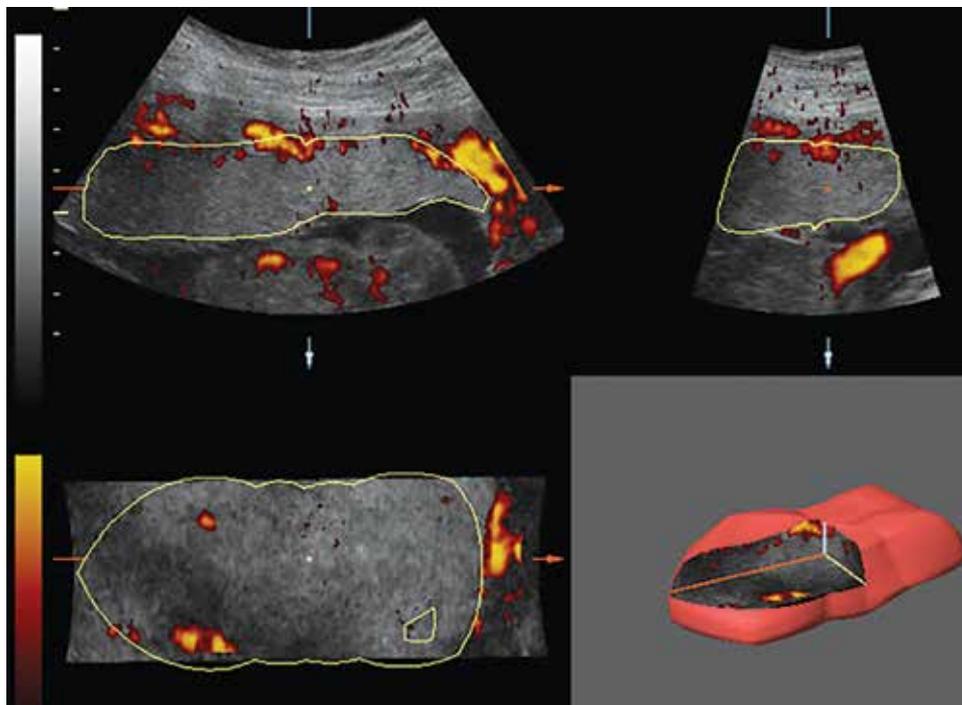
Three orthogonal planes of the placenta. Three-dimensional power Doppler reconstruction is shown in the right lower quadrant (Niche mode)
